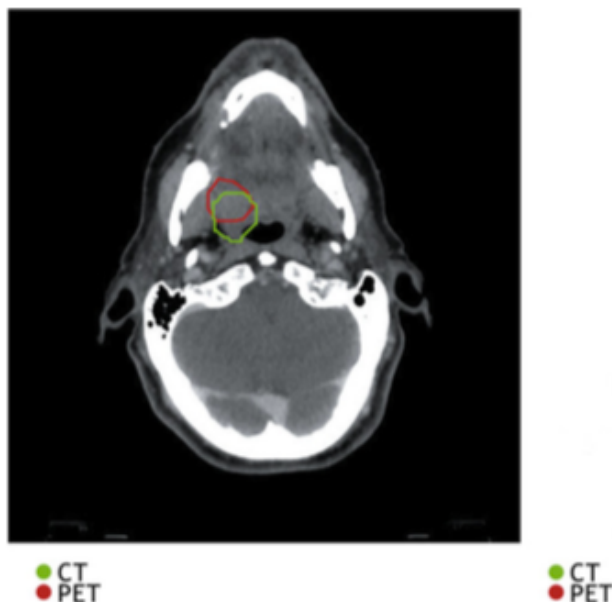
Discordant CT and PET-CT GTV
